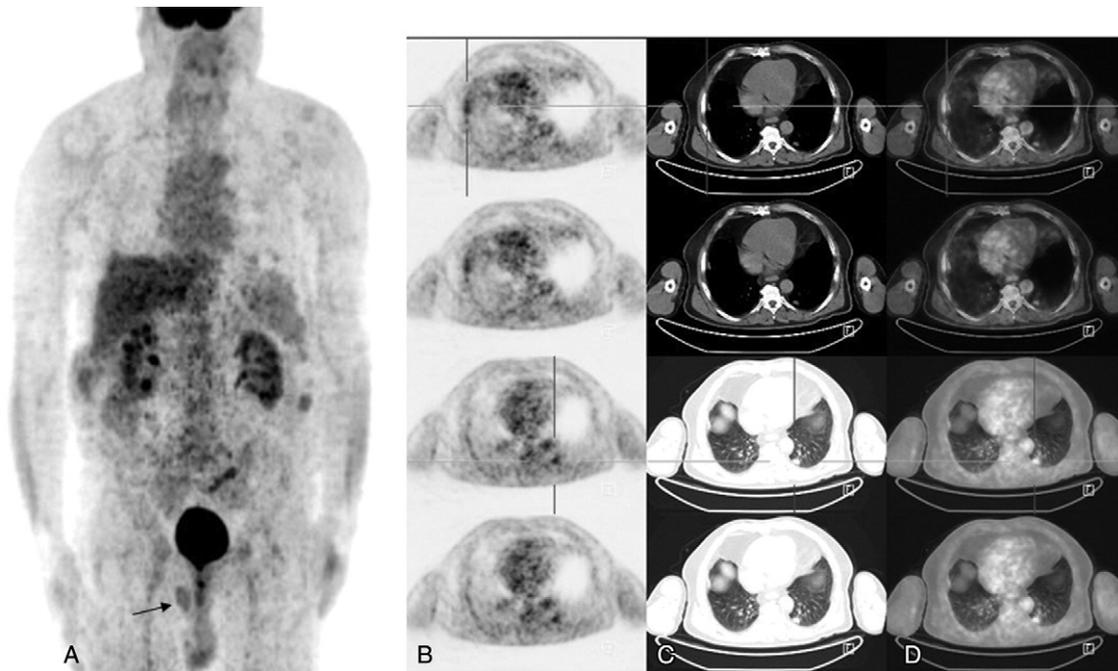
(A) Whole body maximum intensity projection image. Routine PET/CT images from top of skull to mid-thighs acquired 60 minutes after intravenous injection of 10 mCi of fluorodeoxyglucose per standard protocol. On fluorodeoxyglucose-PET/CT imaging, a 16 × 11-mm nodular lesion with increased fluorodeoxyglucose uptake was detected on postero-basal segment of left lung (maximal standardized uptake value [SUVmax] 2.87) and pleural thickening with increased fluorodeoxyglucose uptake observed at right hemithorax (SUVmax 2.9). (b) Axial positron emission tomography scan. (c) CT scan. (d) PET/CT fusion. In addition, spherical lesion with radiotracer uptake (SUVmax 3.33) at right inguinal region that appears separated from vesical activity detected on PET imaging (Fig. a, arrow). Left testis in normal localization (SUVmax 3.57). Left normal testis had same SUVmax as right undescended testis.
